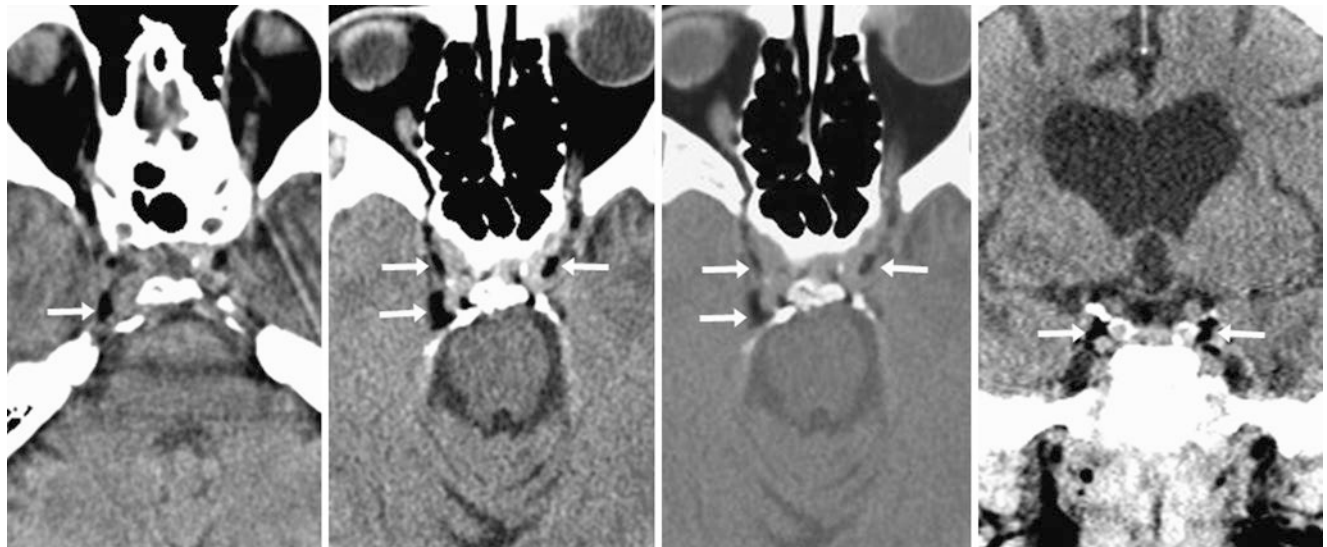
A 39-year-old female post trauma with an otherwise negative head CT scan. There was normal cavernous sinus fat bilaterally (*arrows*) on the brain windows (*left*). A NECT 10 years later demonstrated that
